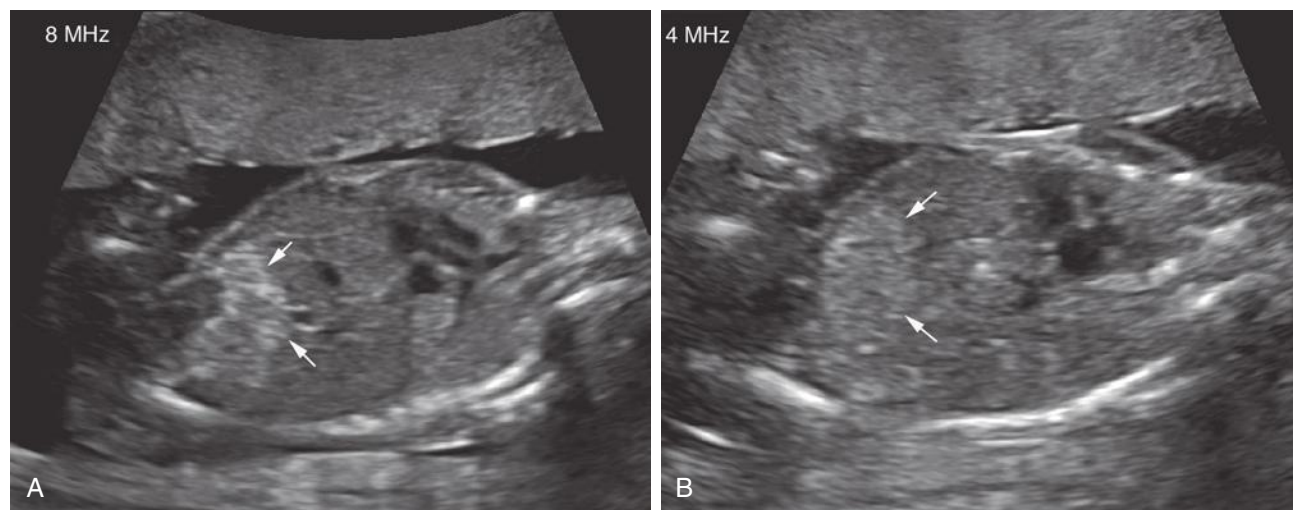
Pseudo-hyperechogenic fetal bowel. A, Sonogram of the fetal abdomen obtained with an 8-MHz frequency transducer demonstrates hyperechogenic fetal bowel (*arrows*). The bowel wall is accentuated at this frequency. B, Sonogram of the same patient obtained with a 4-MHz frequency transducer demonstrates more normal-appearing fetal bowel (*arrows*). This is a common phenomenon and the sonologist should be aware of the effect of transducer frequency on apparent bowel echogenicity. Caution should be taken before declaring abnormal bowel echogenicity and prompting invasive testing.
